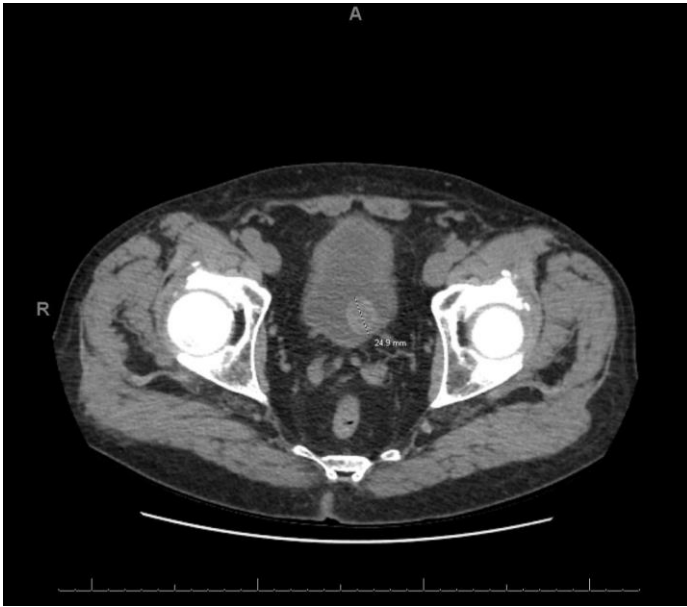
Abdominal CT revealed a 2.5cm urinary bladder soft-tissue mass, confirmed after resection to be low-grade papillary urothelial carcinoma.
